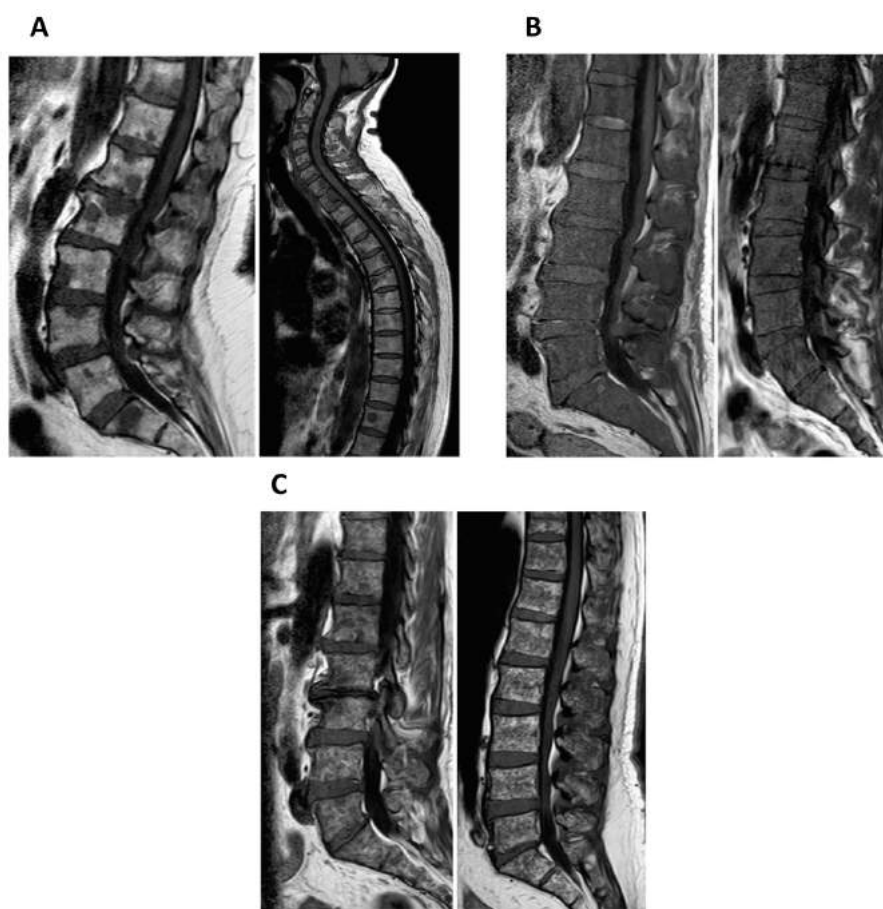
Appearances of focal, diffuse and variegated pattern on T1-weighted images. (A) Focal pattern: On T1-weighted images, focal lesions are darker than yellow marrow and slightly hypointense or isointense to intervertebral disc and muscle. (B) Diffuse pattern: On T1-weighted images, the abnormal process replaces the normal bone marrow signal, and the diseased marrow appears darker or isointense to the intervertebral discs. (C) Variegated pattern: On T1-weighted images, the bone marrow is very inhomogeneous with innumerable small lesions [26].
